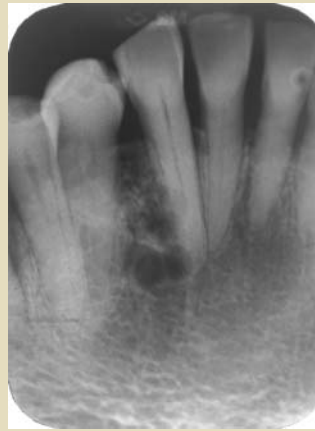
A current periapical radiograph exhibits a well-defined multilocular radiolucency.
